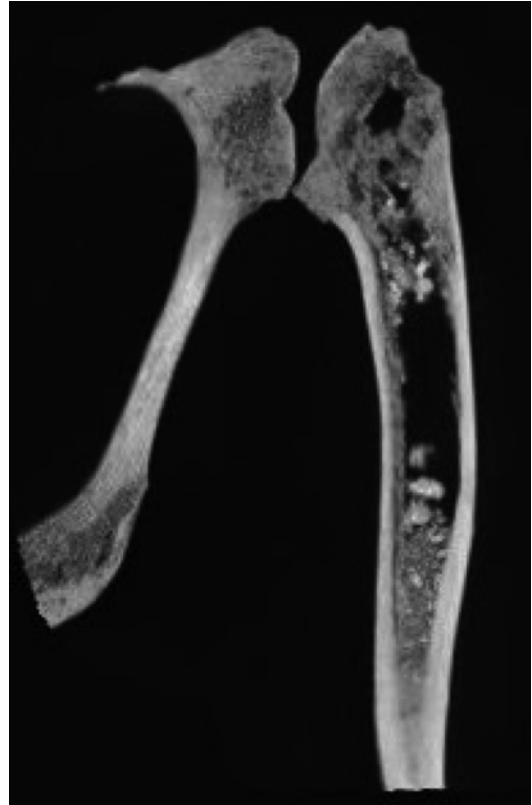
(Left side detail): coronal plane multiplanar reconstruction CT scan: presence of structured hyperdensity precipitates with a "cobblestones" feature in the bone marrow and thinner adjacent cortex
